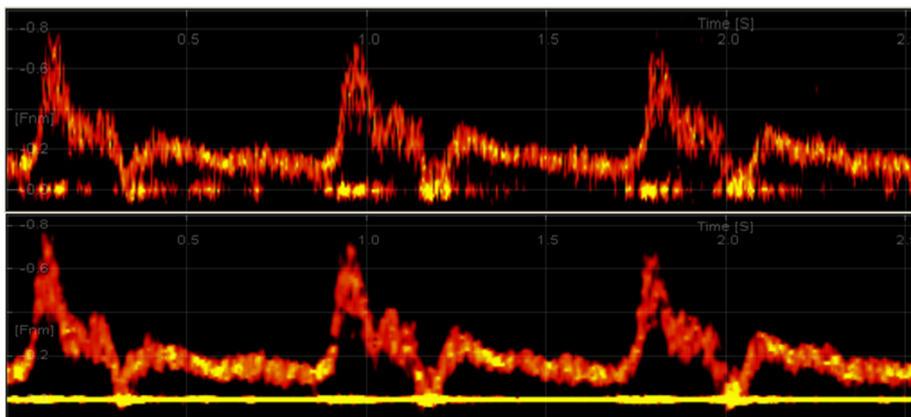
ULA-OP real-time software display of two sonograms relating to the signal coming from the carotid artery of a healthy volunteer. On top, the sonogram obtained through the APES method with 31 samples; on bottom, the sonogram obtained through the conventional approach (FFT) using 128 samples.
